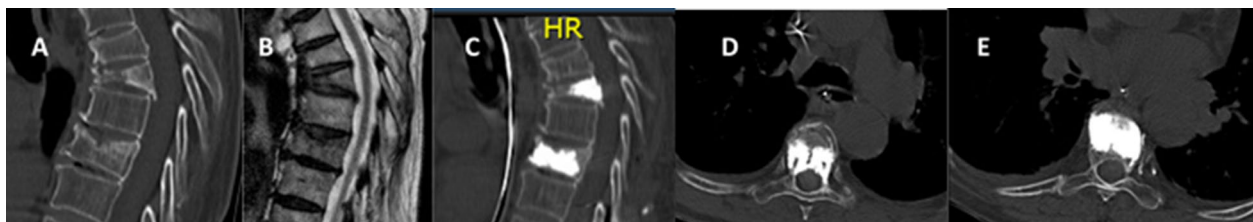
A, B Sagittal CT and MRI of osteoporotic thoracic vertebral fractures (T4 and T6); T4: OF type 3, T6: OF type 2. C–E CT scan (sagittal and axial) after PVP of both vertebral fractures without complications
